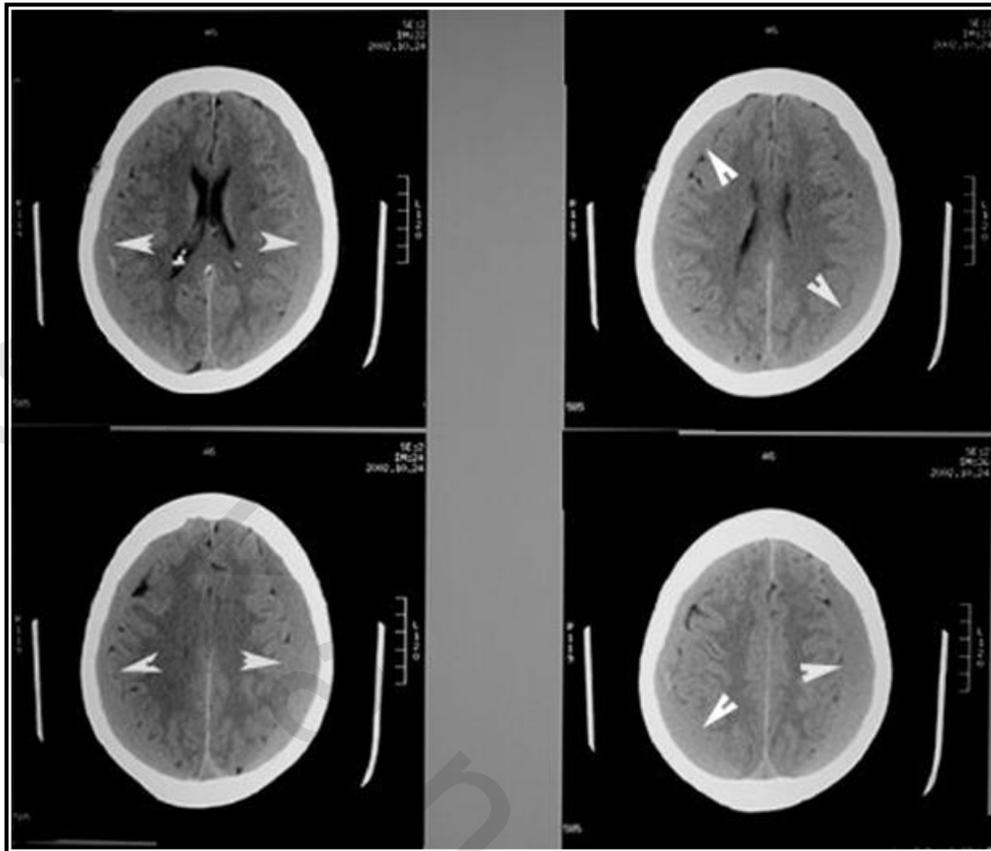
Radiological features of bilateral CSDH in CT brain. These are bilateral and are isodense with the brain because of gradual loss of density of blood. On close exam you see that the sulcal markings do not reach the surface of the skull, due to the intervening subdural collection. Arrowheads point to subdurals separating the brain surface markings from the skull. There is no midline shift.
